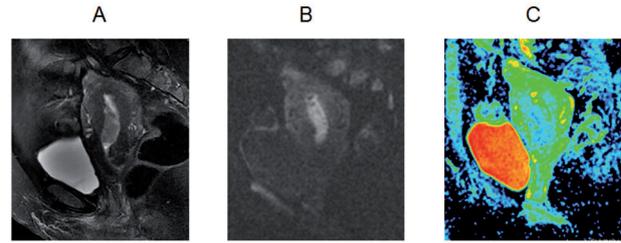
Well-differentiated endometrioid adenocarcinoma (grade 1). (a) Sagittal T2-weighted image shows a tumor in the endometrial cavity. (b) DWI shows an increased signal intensity corresponding to the endometrial tumor. (c) ADC map image shows the tumor as a slightly hypointense area compared with normal parenchyma.
